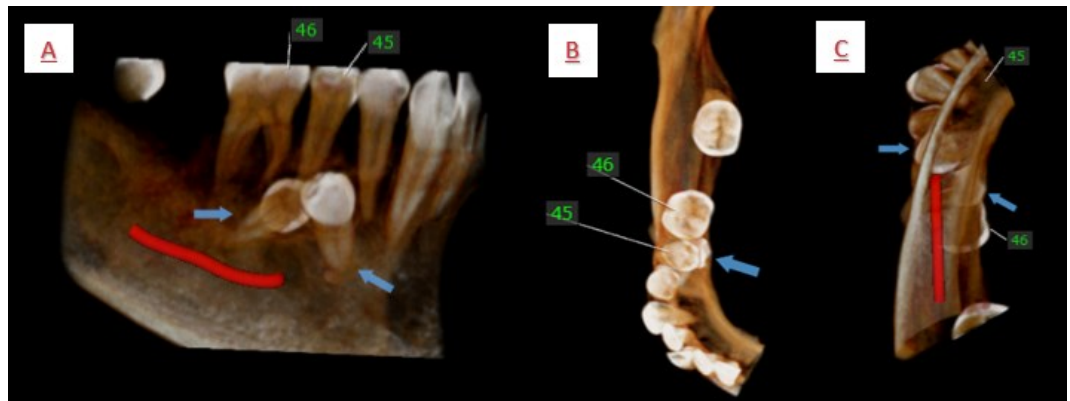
3D CBCT images, (A) buccal view, (B) Occlusal View, and (C) apical View
